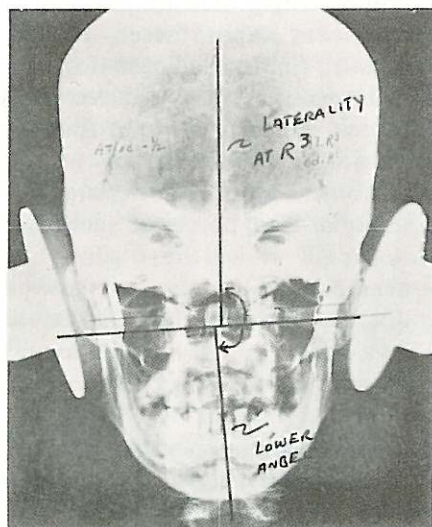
Laterality and Lower Angle Determined by X-ray Analysis.
